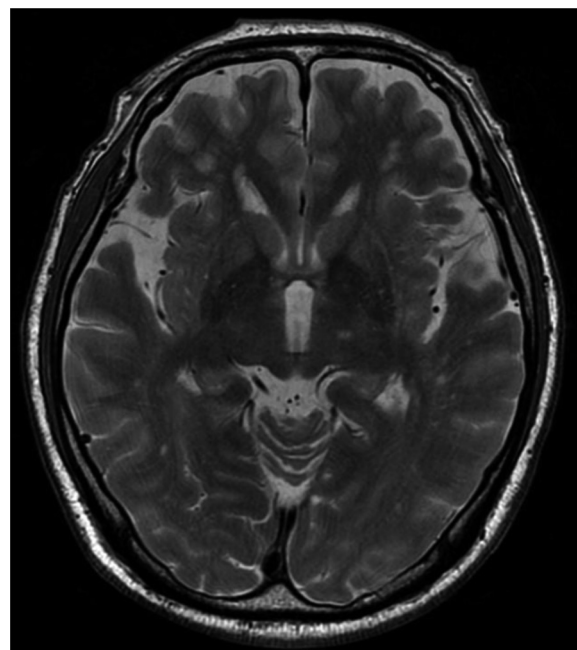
T2 weighted magnetic resonance image (MRI) of the head. After the magnetic resonance (MR)-guided focus ultrasound treatment against the left ventral intermediate nucleus, T2 MRI was obtained. The edematous focus of sonication showed a hyperintensity signal.
